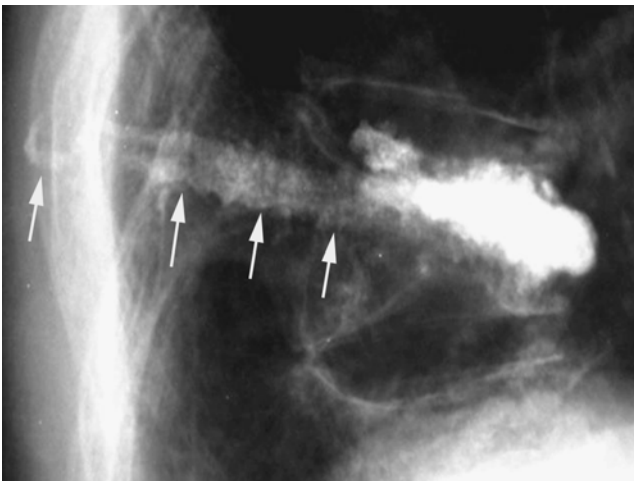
Lateral radiograph showing cement that was too liquid when injected that tracked backward along the needle path, leaving cement in the soft tissues (white arrows). This can happen easily when using cements with long work times (i.e., Cranioplastic, Vertebroplastic, or Secore).
